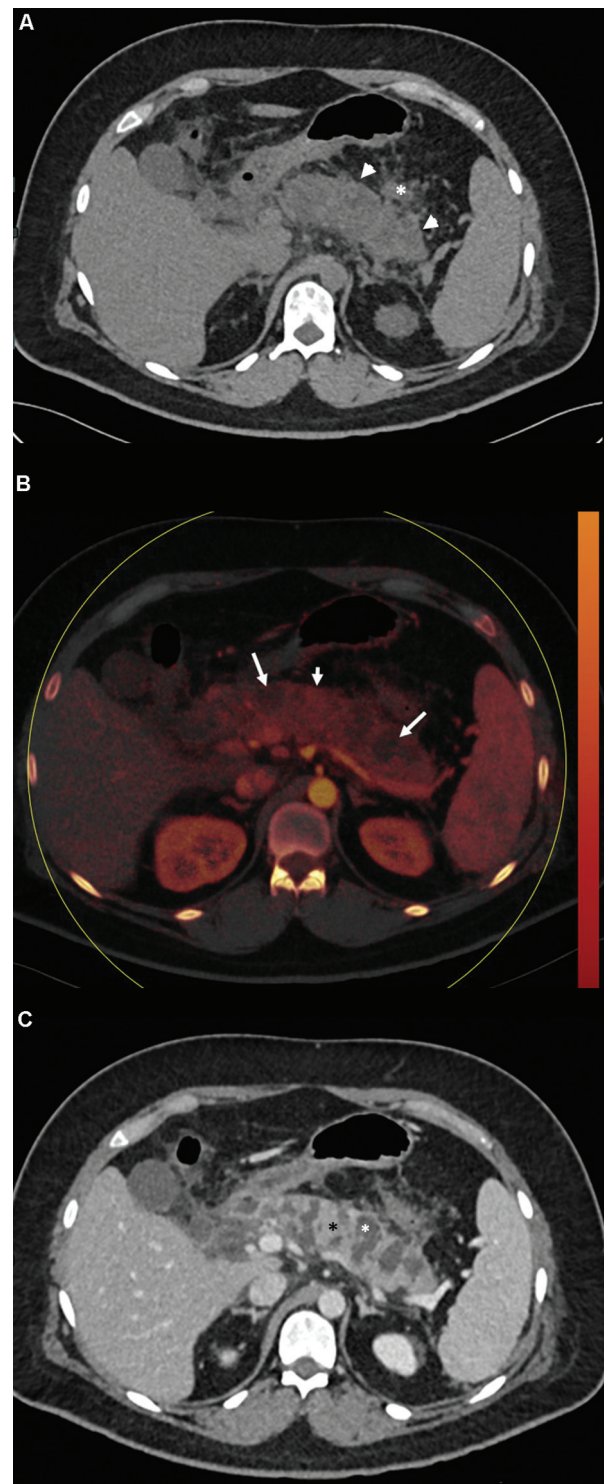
Dual-energy computed tomography (CT) in a 27/M with acute alcohol-related necrotizing pancreatitis due to binge drinking. (A) Noncontrast-enhanced CT (NECT) in axial plane done 72 hours after acute pain following alcohol binge with a history of alcohol abuse, shows bulky pancreas (white arrowhead) with heterogeneity. The white star represents peripancreatic edema. (B) Dual-energy iodine image (late arterial phase) showing multiple focal areas of lack of iodine/enhancement (long white arrow). The short white arrow represents iodine/enhancement in the intervening areas. (C) Contrast-enhanced CT (CECT) (portovenous phase) at the same level as B shows bulky pancreas with multiple necrotic areas (white star) alternating with enhancing areas (black star) corresponding to image B.
